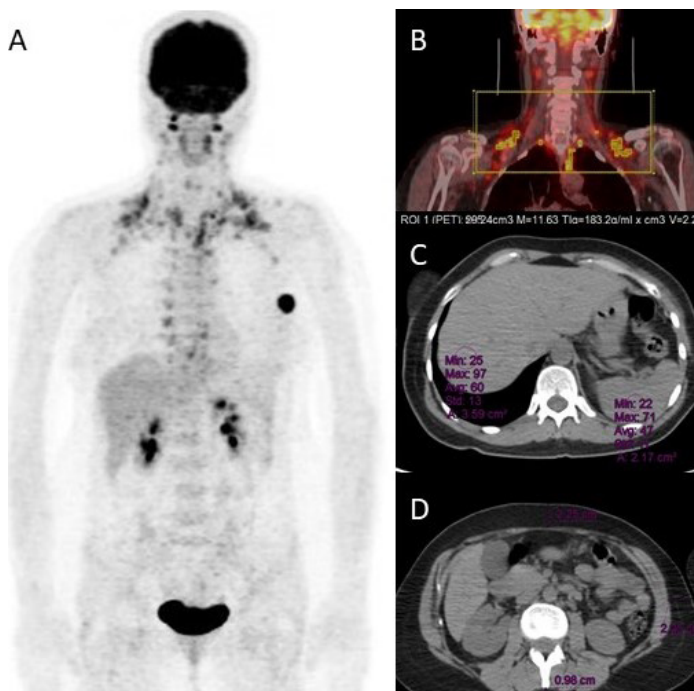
Maximum intensity projection image of whole body 18F-FDG PET study with an intense 18F-FDG uptake in the neck and supraclavicular region symmetrically (A). Coronal PET/CT fusion image of the neck and upper thorax demonstrating the region of interest drawn over the 18F-FDG avid brown adipose tissue with the given threshold and automatically calculated quantitative indices (B). Regions of interests drawn to calculate hepatic and splenic attenuation index (C) and subcutaneous adipose tissue thickness at L3 vertebra level (D). Additionally, hepatic attenuation index and SCATT were calculated from CT images. A blinded reviewer studied non-contrast PET-CT scans to determine the amount of SCATT. The
